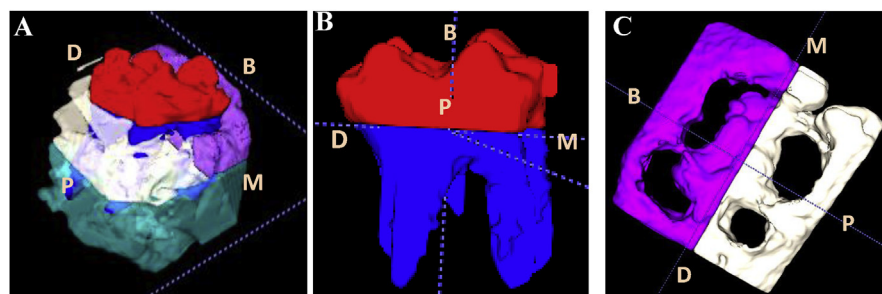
Segmentations of 3D model of CBCT image. A: Color assignments for different portion of target molar and surrounding alveolar bone; B: Segmented molar from alveolar bone. Red and blue colors indicate molar crown and roots, respectively. C: Segmented alveolar ridge, purple and white colors indicate buccal and palatal ridges, respectively. M: mesial; D: distal; B: buccal; P: palatal.
